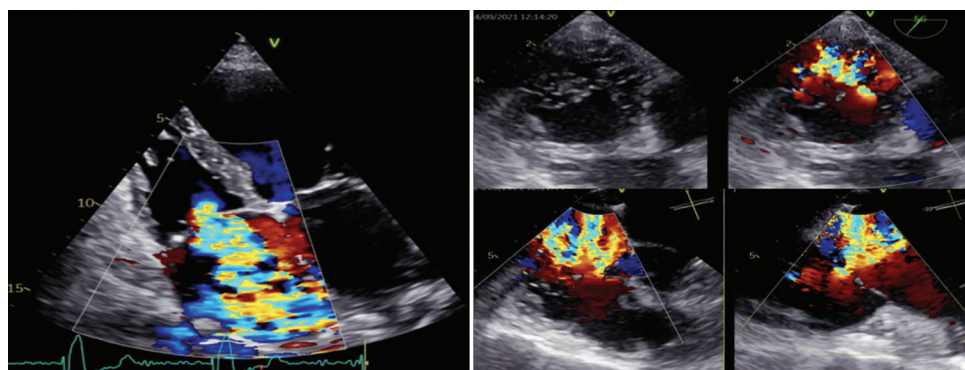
Massive tricuspid regurgitation with prevalent jet localized in the antero-septal area: TTE apical window right ventricle focused 4 chambers view; Transesophageal echocardiography (TOE) (left) transgastric short axis view (top) and mid-esophageal 4-chamber view with multiplanar reconstruction (MPR) (bottom)
